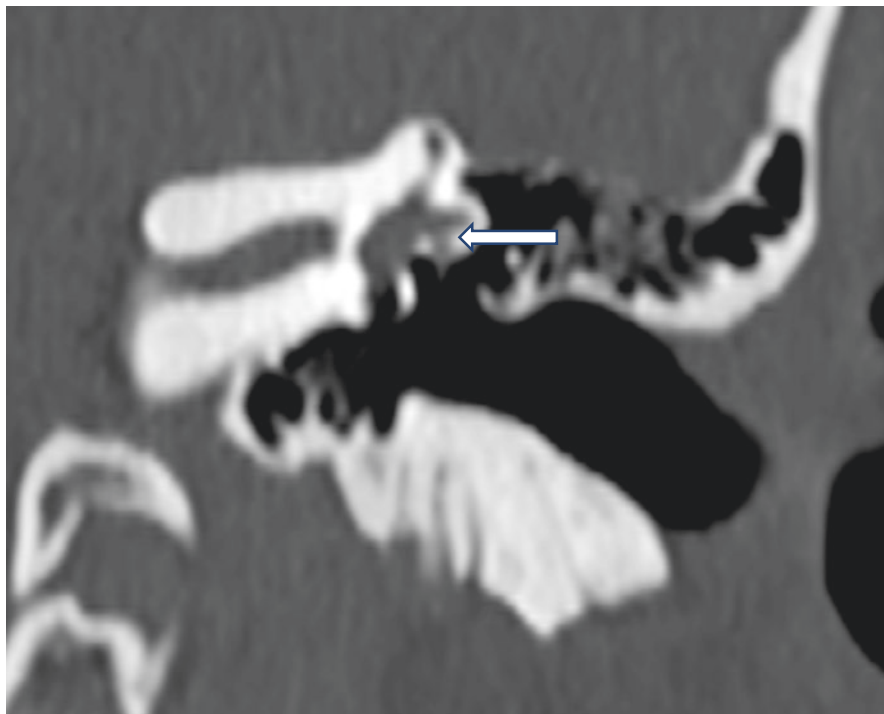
Coronal CT scan demonstrating a defect along the lateral semicircular canal communicating with the facial nerve canal
